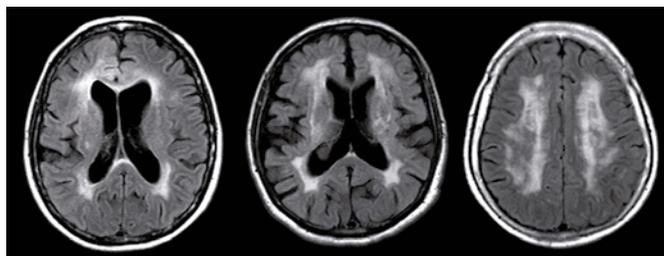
Cerebral MR with axial FLAIR sequences. 63-year-old patient with vascular dementia associated to severe confluent leukoencephalopathy.
